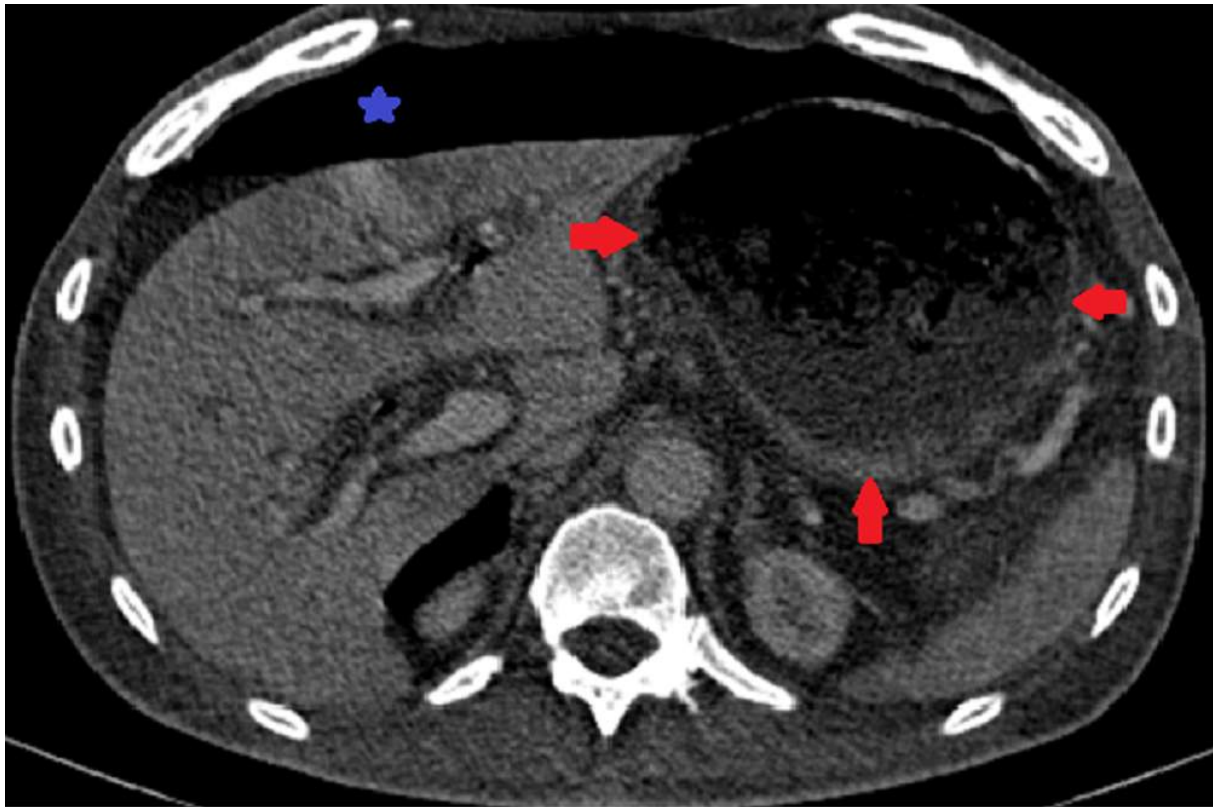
Abdominal and pelvic CT injected at the portal phase in axial section showing a stasis stomach (red arrow) in a patient on the 7th postoperative day who presented with intermittent vomiting. Note a postoperative pneumoperitoneum (blue star)
